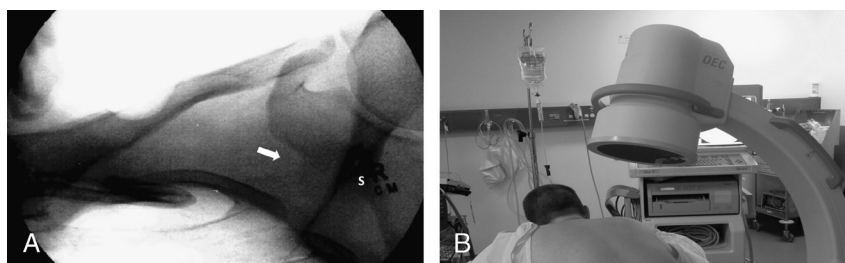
A, Radiograph of the right suprascapular notch. S indicates spine of scapula. White arrow points to the suprascapular notch. B, C-arm positioning for imaging the suprascapular notch. The patient is placed in prone position. The C-arm is positioned over the shoulder. To image the suprascapular notch, the C-arm is rotated oblique to the treated side and angled cephalocaudal. Reproduced with permission from Ultrasound for Regional Anesthesia (www.usra.ca).
